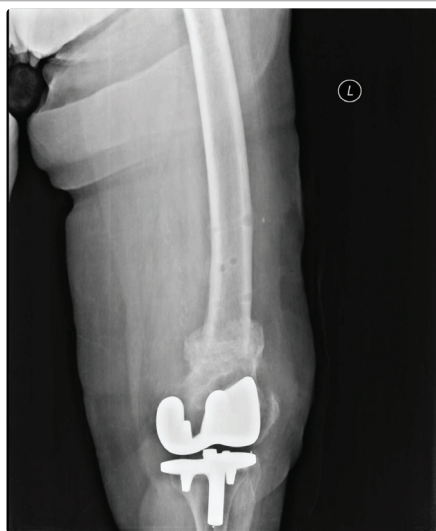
Postoperative AP (4) and lateral (5) x-rays of the same patient showing an uncomplicated full bony healing.
